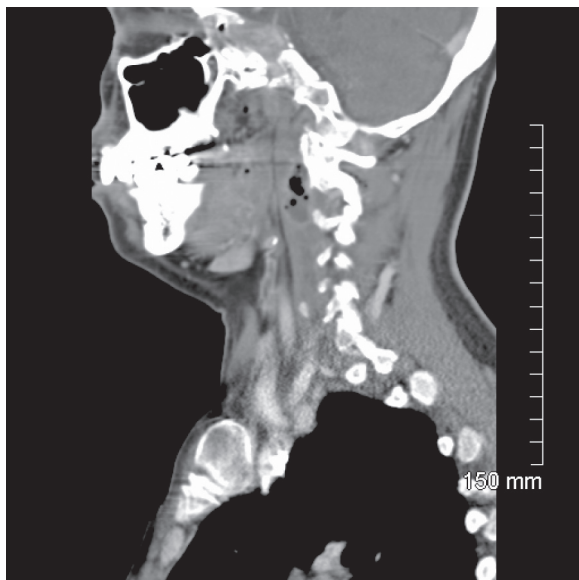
Sagittal CT scan demonstrating right sided retropharyngeal abscess.
